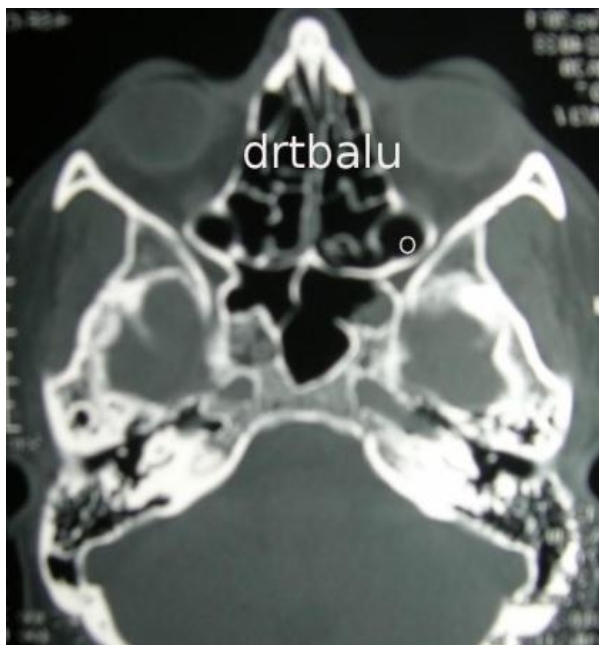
CT scan axial cut showing onodi cell
